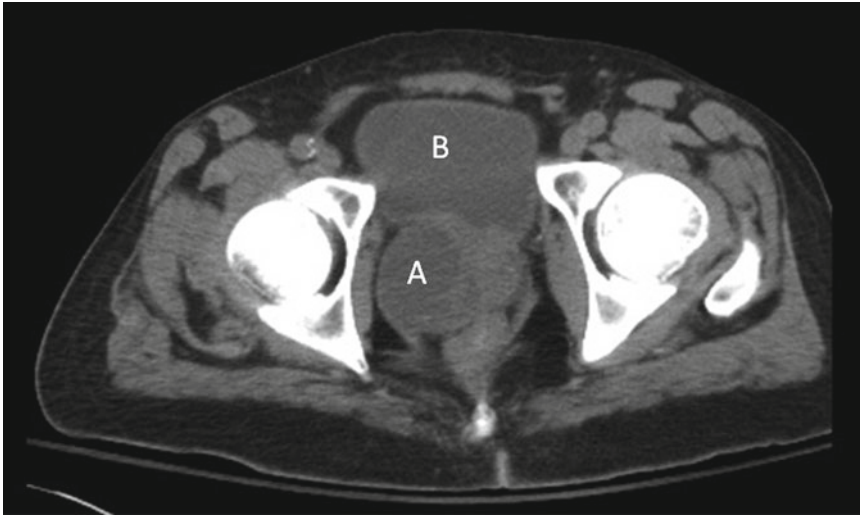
CT scan of prostatic abscess demonstrating large low density collection within right side of the prostate (A) distinct from the low density of the urinary bladder (B)
